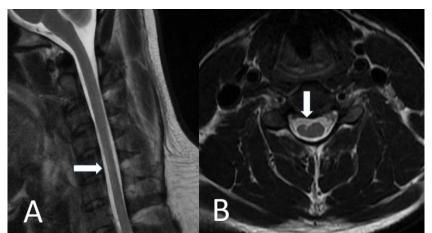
Cervical spine MRI in flexed position sagittal T2 weighted image (A) shows focal linear T2 hyperintensity (white arrow). Axial T2 weighted image (B) shows asymmetrical right hemi-cord flattening at C5 level. No forward falling of posterior dura on the sagittal image
